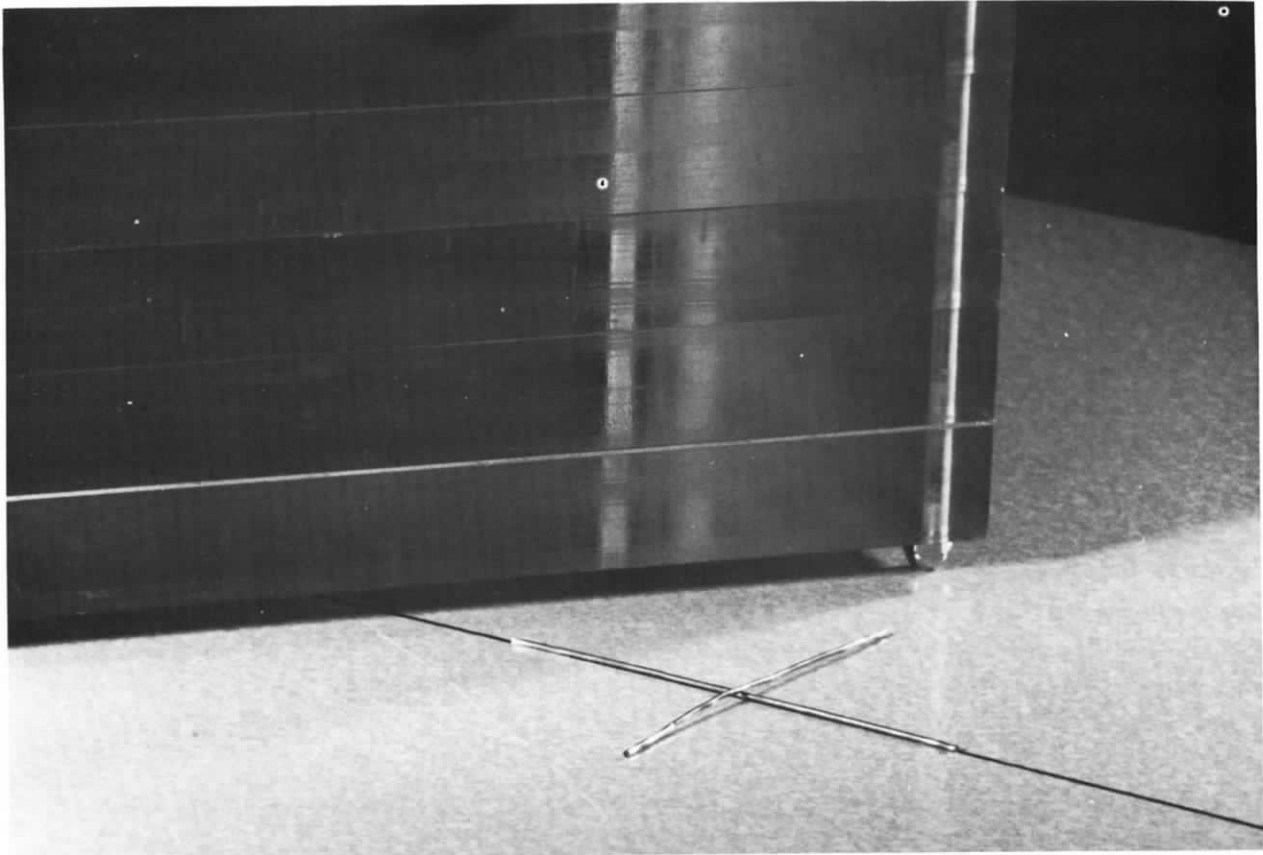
X-ray beam, Bucky grid motion and centering, and image receptor alignment test setup. Lead solder strips should be placed on the tabletop, centered to the collimator cross-hairs, and then the PEP placed on top of the strips.
